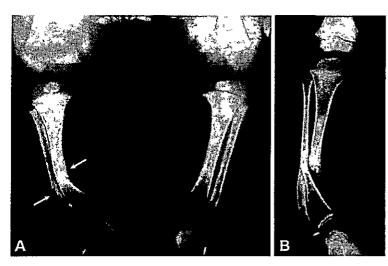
Congenital tibial dysplasia in a child with NF1. (A) Frontal radiograph of the bilateral legs at 1 month of age shows apex anterolateral angulation of the distal shafts of the tibia and fibula on the right (arrows) with medial cortical thickening. (B) Frontal radiograph of the right leg at 3 years of age shows pseudarthrosis of the mid to distal tibia and distal fibular bowing.
